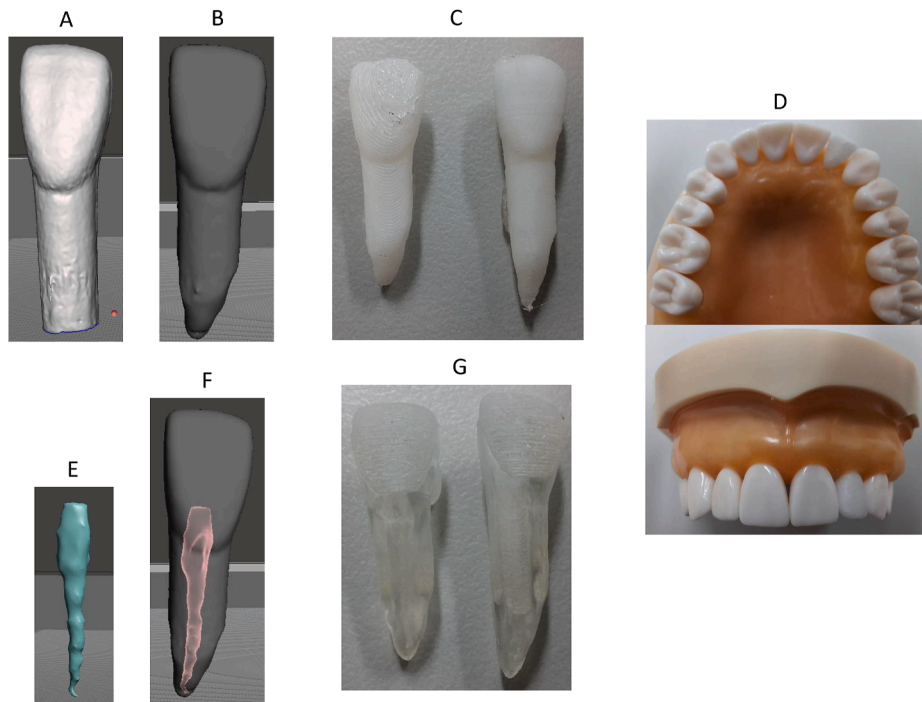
3D scanned and printed tooth. (A) Original tooth model using a dental 3D scanner. (B) Customized design of root. (C) 3D printed tooth model. (D) Printed tooth fit-well in the dental model. (E) Canal structure obtained from cone-beam computed tomography. (F) Pulp structure combined with tooth structure. (G) Final printed teeth with pulp system.
